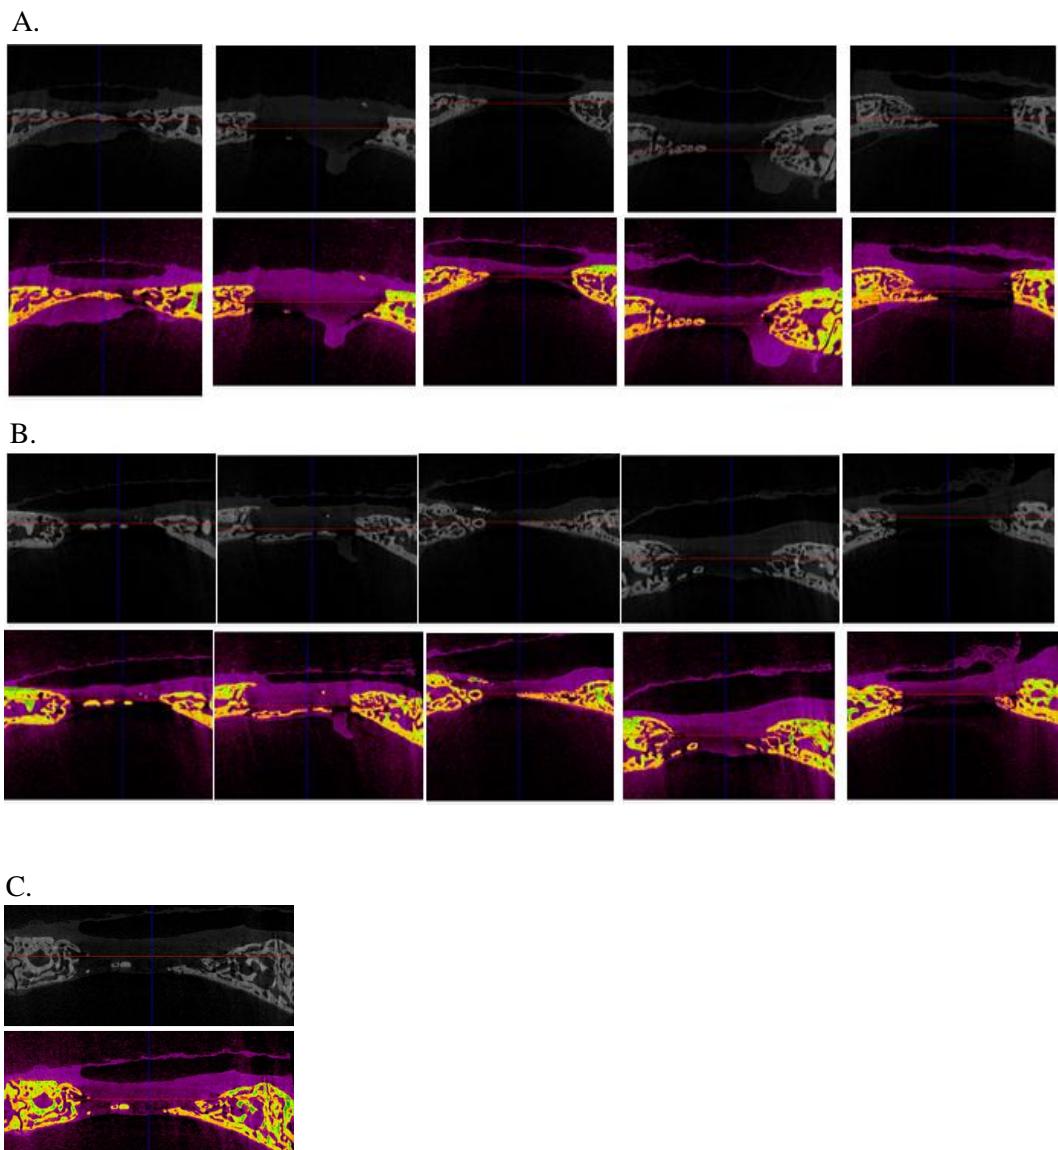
Micro CT images of fibrin applied defects at 8 weeks. A. Fibrin alone applied defect. B. Fibrin+TAT-BMP-2 5 μ g applied defects. C. Fibrin+TAT-BMP-2 2 μ g applied defect.
